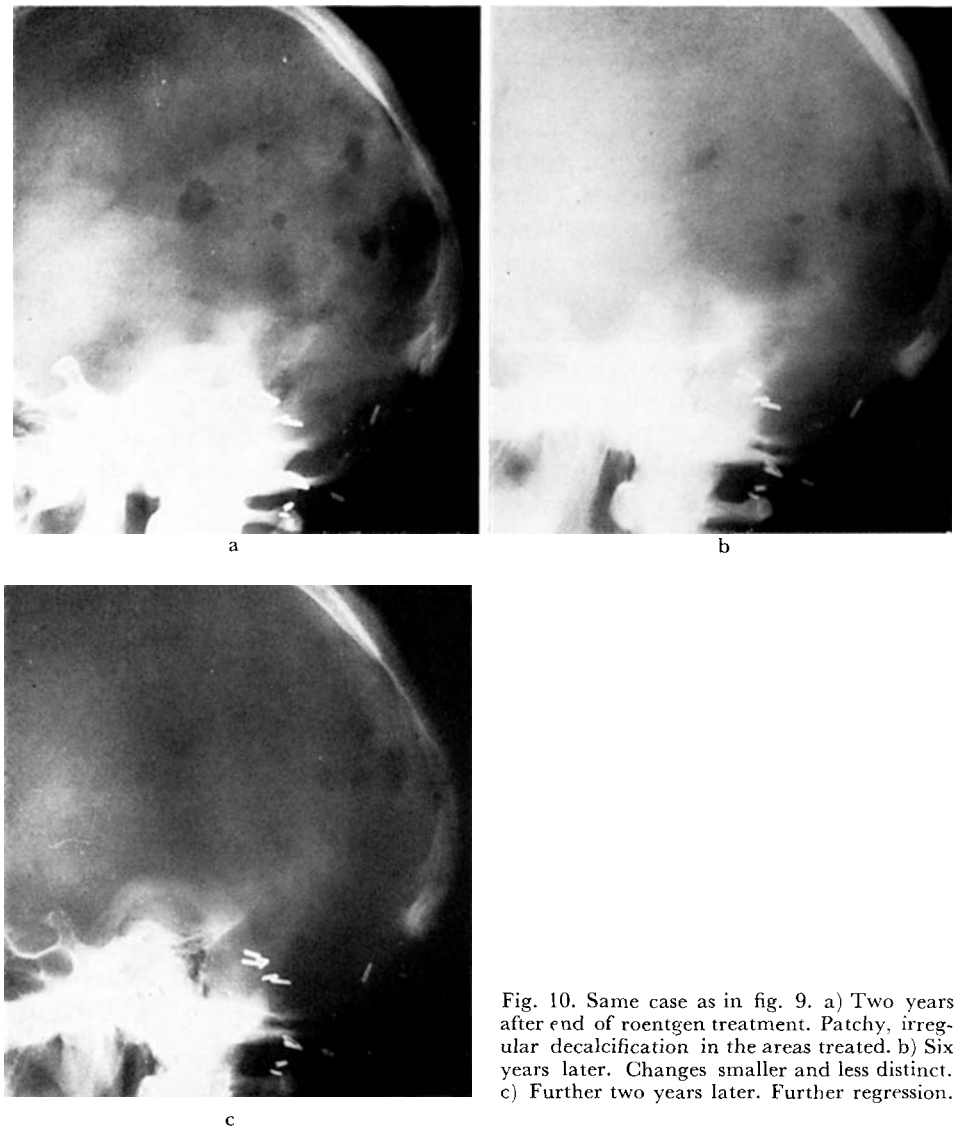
Same case as in fig. 9. a) Two years after end of roentgen treatment. Patchy, irregular decalcification in the areas treated. b) Six years later. Changes smaller and less distinct. c) Further two years later. Further regression.
